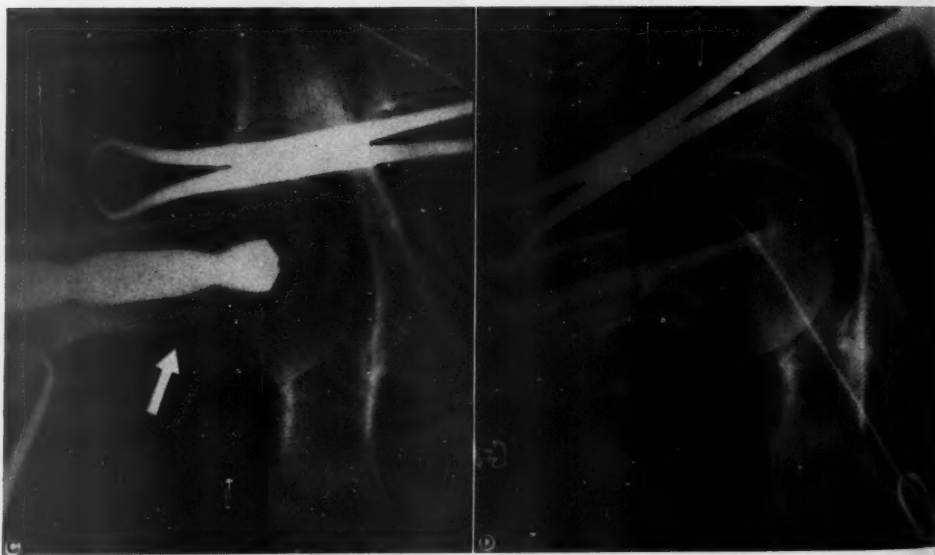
C*, roentgenogram of the fracture shown in the lateral view of figure 6, *A* and *B*, showing the fracture reduced, the drill point in place, and the splintered posterior cortex (indicated by the arrow). *D*, roentgenogram in the lateral view of the fracture shown in figure 6, *A* to *C*, with the Collapatite peg in place, and the fragments of the posterior aspect of the neck of the femur in place.
